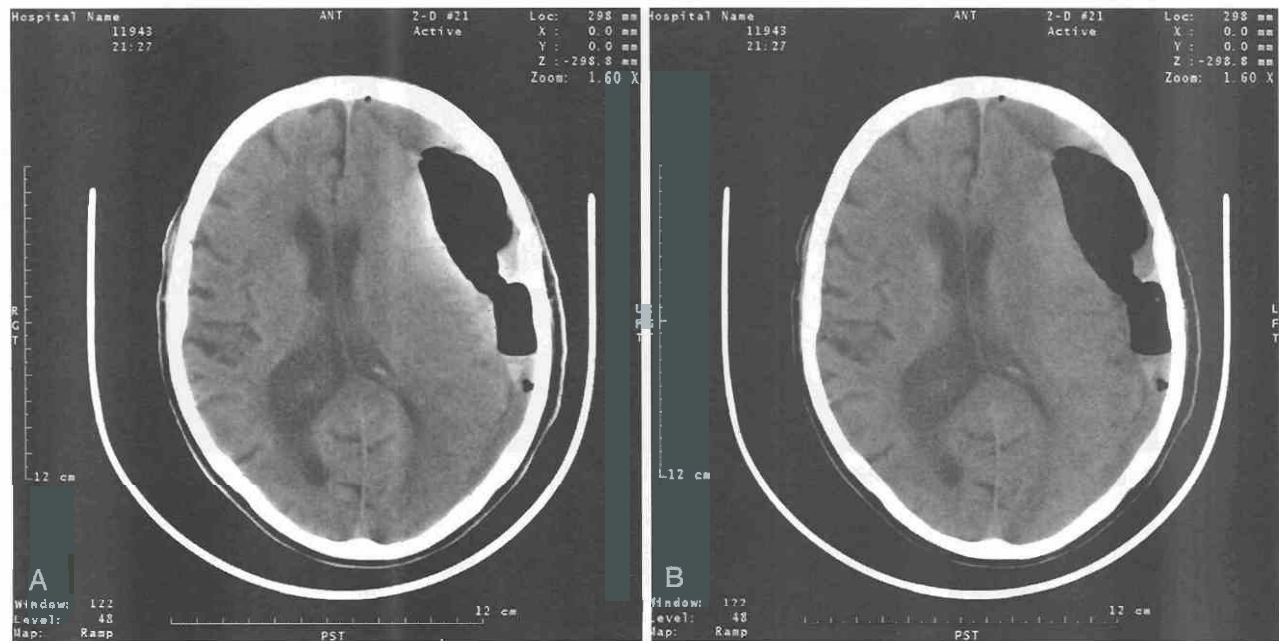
Beam-hardening artifacts. *A*, Postoperative CT image of the brain in an adult. *B*, Comparison of reductions in beam-hardening artifacts with use of iterative reconstruction technique. *A* corrected image using UltraImage reconstruction technique. (Courtesy of Marconi Medical Systems.)
